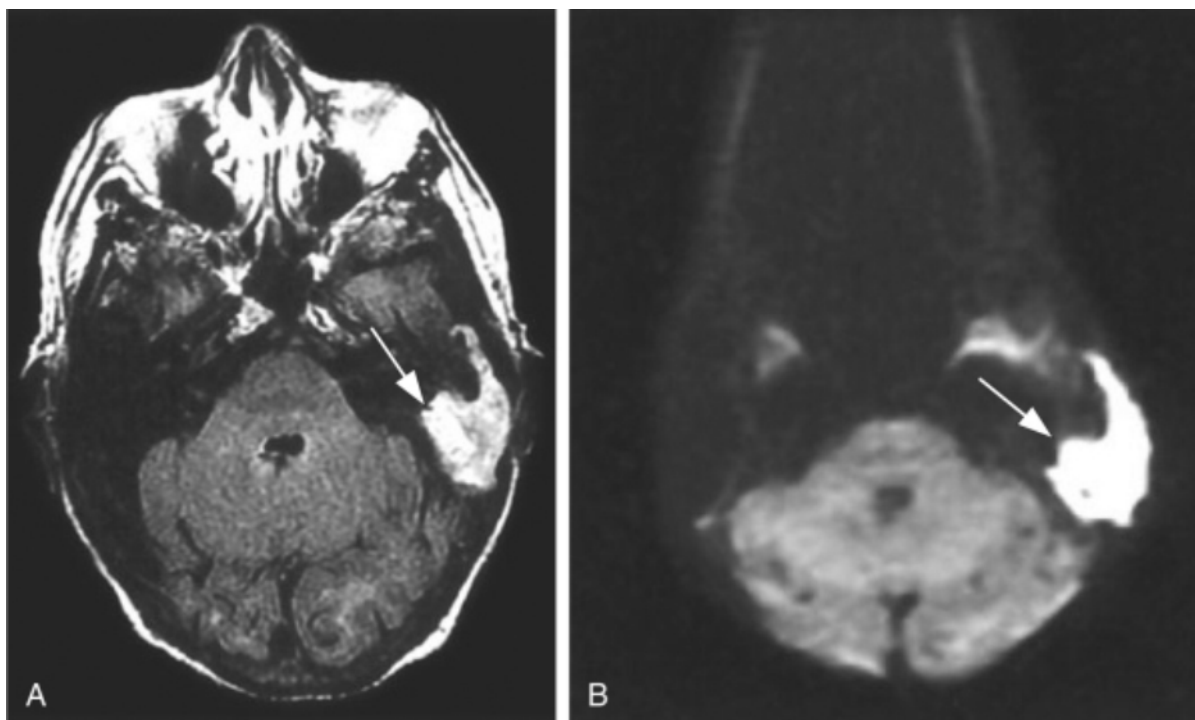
Petrous apex cholesterol granuloma, preoperative views. A, T1-weighted magnetic resonance image (MRI), without contrast enhancement, demonstrating a bright left petrous apex lesion (*arrow*) that is isointense with fat. B, T2-weighted MRI showing a bright left petrous apex lesion (*arrow*) that is isointense with cerebrospinal fluid and perilymph.
